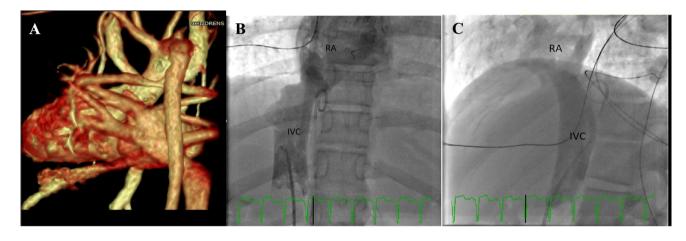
A 3D reconstruction of pre-Fontan cardiac MRI demonstrating the IVC draining into the atrium. B, C AP and lateral view of preoperative Cath showing unobstructed flow of contrast from IVC to right
